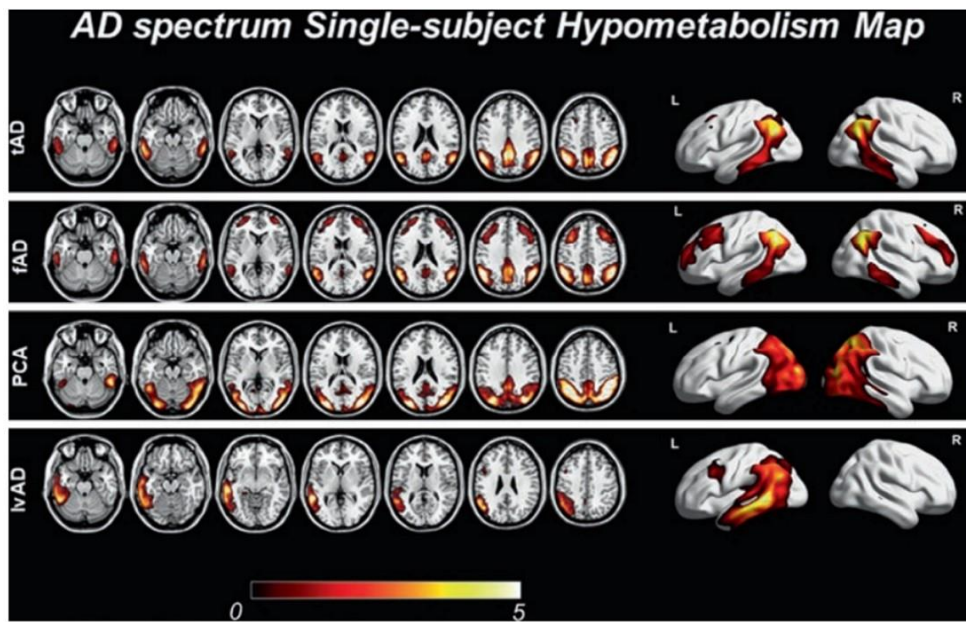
Specific single-subject [^{18}F]FDG-PET hypometabolism patterns in Alzheimer's disease subtypes (source: Perani et al., 2020).
